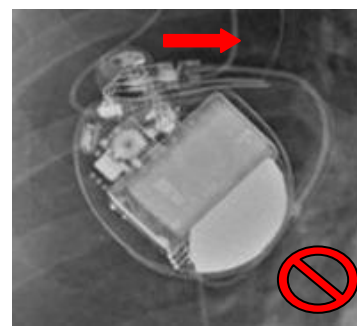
Photo and X-ray. Avoid this orientation for subpectoral implants. Leads exit in a clockwise direction. Serial number is facing the ribs.
